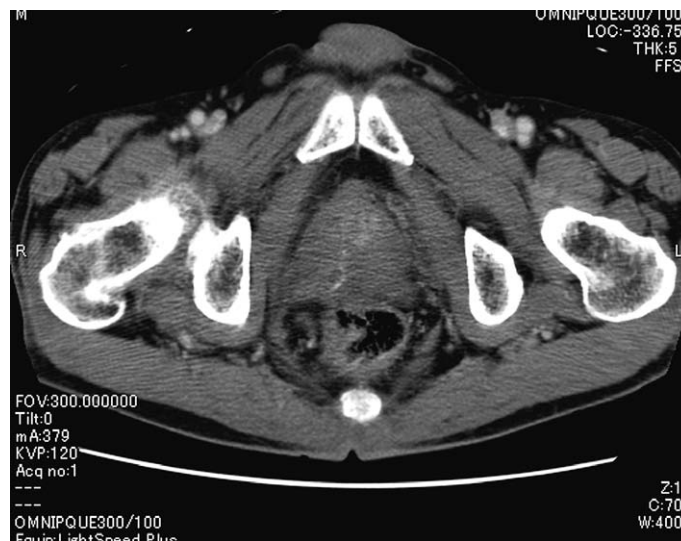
At two months after transurethral drainage CT showed no recurrence of abscess in the prostate.
